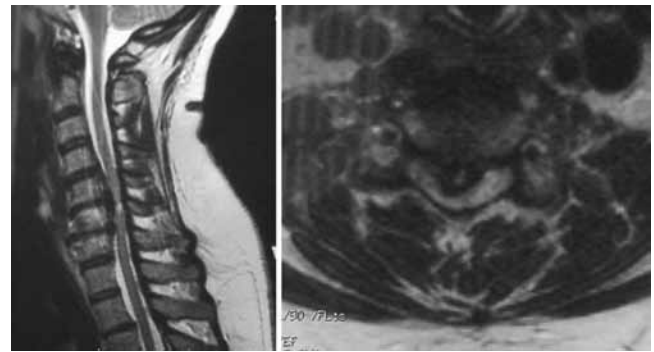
Images obtained in a 49-year-old Black woman initially misdiagnosed with cervical spondylotic myelopathy. Sagittal (left) and axial (right) MR imaging shows morphological characteristics suggestive of continuous type OPLL from C-5 to C-7.
